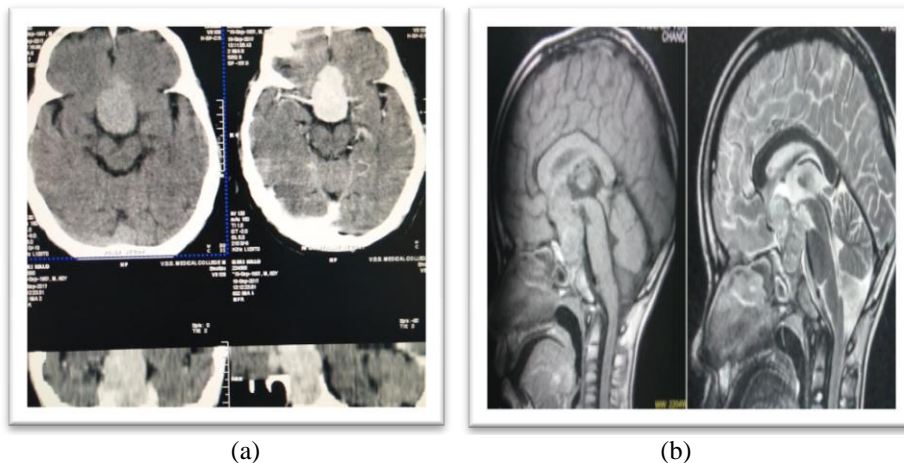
(a) CT image shows a homogeneously hyperdense lesion causing expansion of suprasellar cistern which takes intense enhancement on IV contrast administration. (b) T1 and T2 images. The picture on extreme right shows T2 hyperintense microcysts in the same cases. Diagnosis was pituitary macroadenoma.
